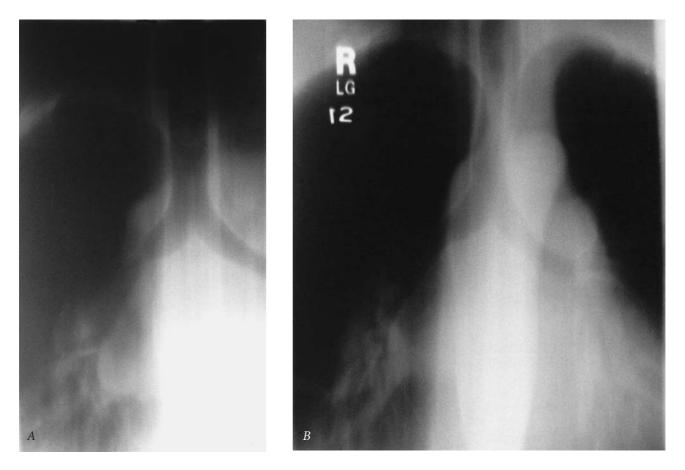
A, Tracheal tomogram demonstrating an anastomotic stenosis. The airway stenosis can be seen at the level of the anastomosis in this patient's post-right single lung transplantation for pulmonary fibrosis with secondary pulmonary hypertension. The stenosis was treated by dilatation and stent placement. B, Tracheal tomogram following stent removal. The patient demonstrated in A had an indwelling Silastic stent placed after dilatation of the anastomotic stenosis. The stent was removed after 14 months and subsequently did not recur. A normal anastomotic caliber can be appreciated on this radiograph.
